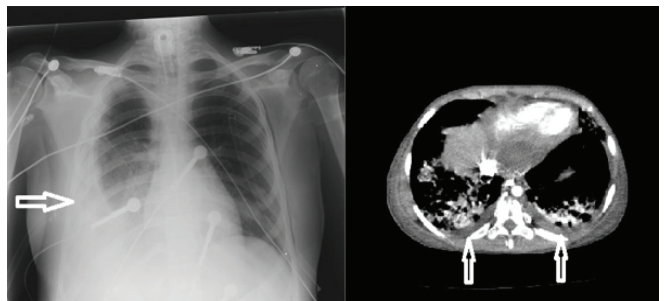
The pleural fluid is demonstrated on X-ray (right) and CT (left) (arrows)
